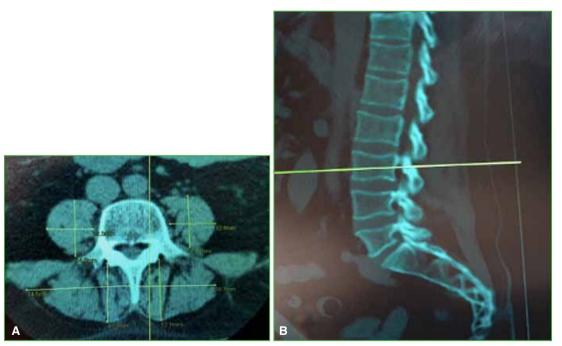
CT scan showing measurement of psoas muscles and paravertebral gutter muscles. A. Axial section. B. Sagittal section. Level where the measurements are made (height of the pedicles).
